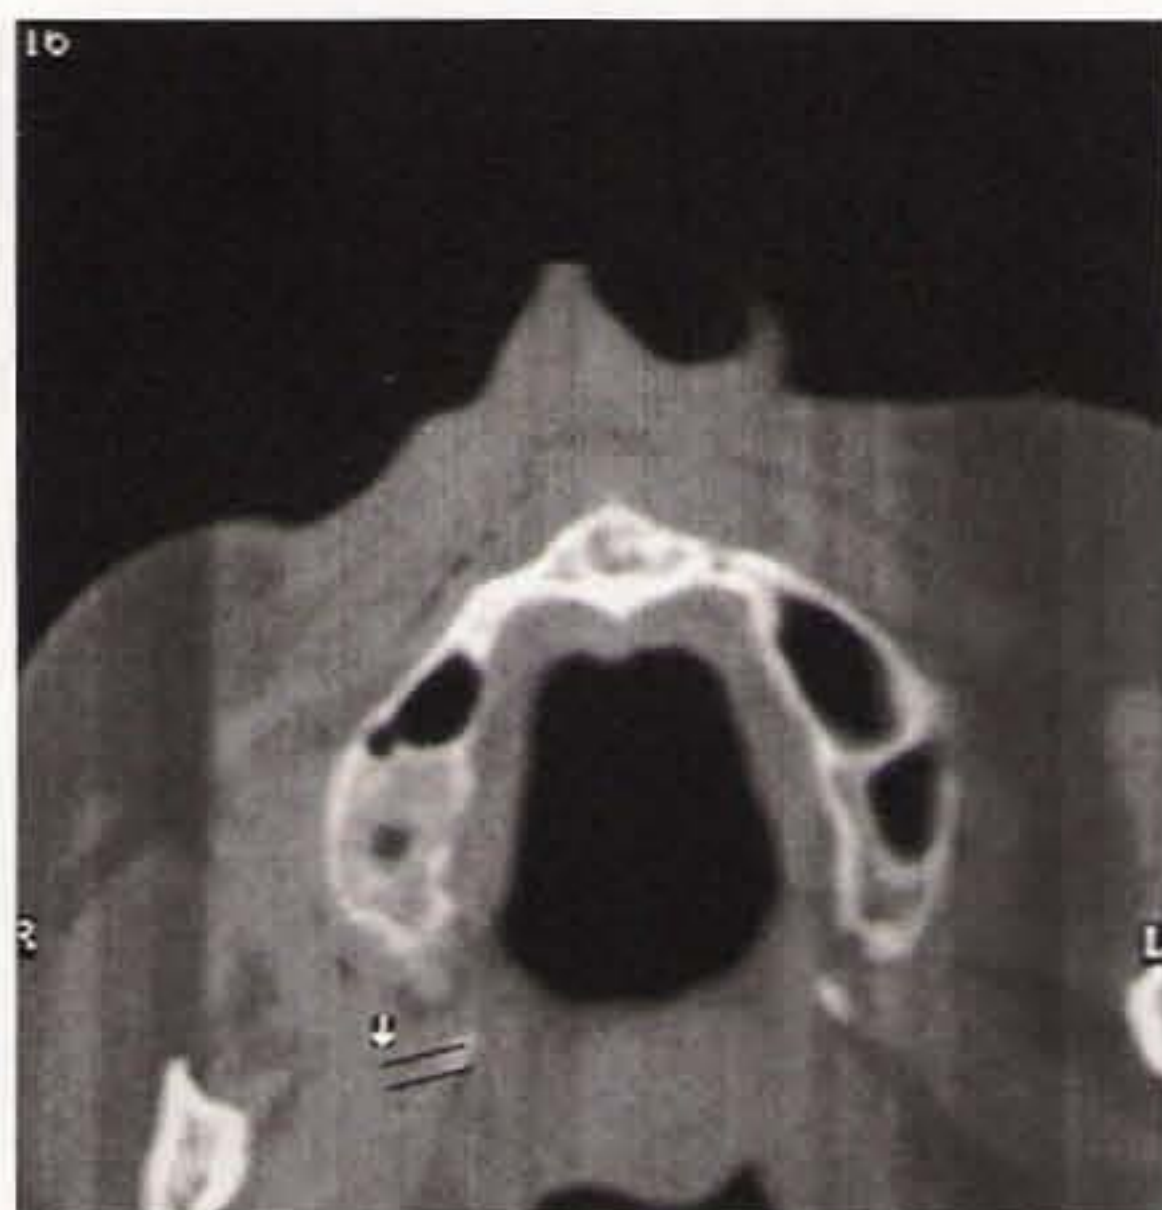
The CT scan indicates serious atrophy of the maxilla.
